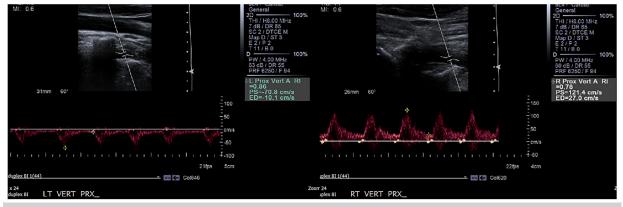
Carotid duplex ultrasound revealing retrograde flow in the left vertebral artery.
